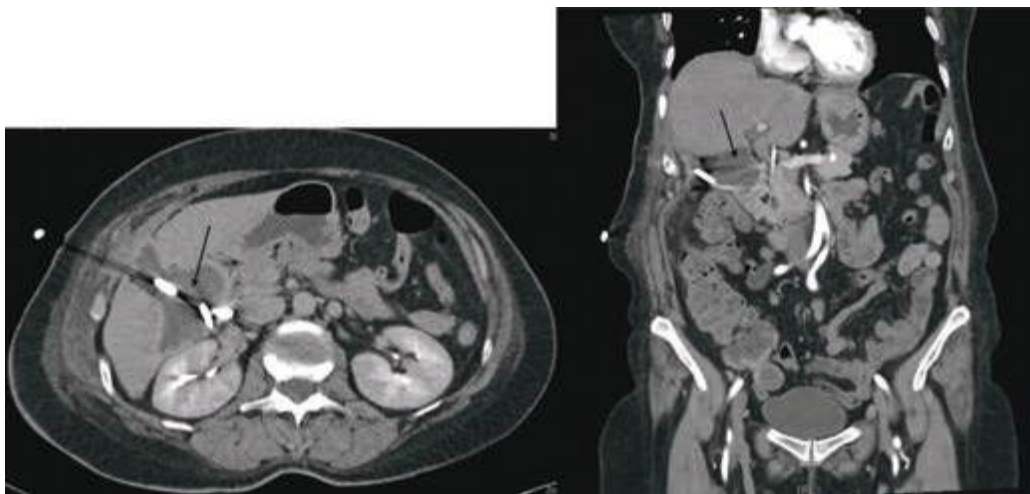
Follow-up contrast-enhanced CT demonstrating significant regression of the previously drained biloma with the drainage catheter in situ. Only minimal residual fluid remains (arrow).
